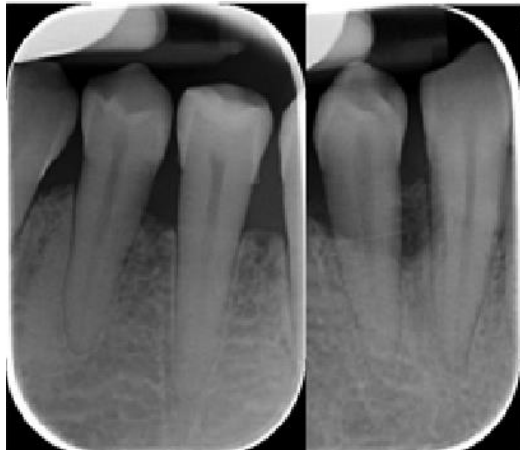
Rx retroalveolar mandibular radiographs
